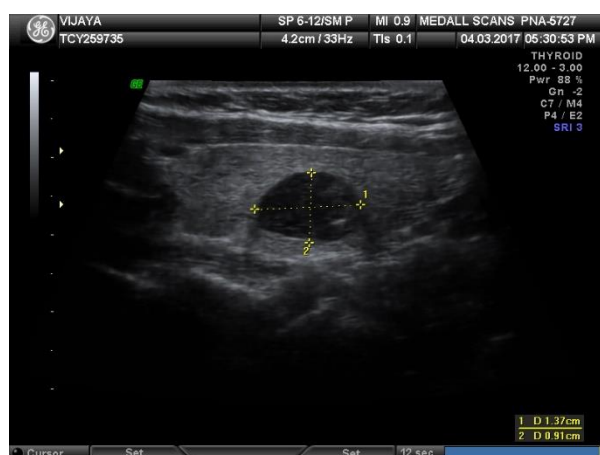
Ultrasound images of reactive cervical lymph nodes.
